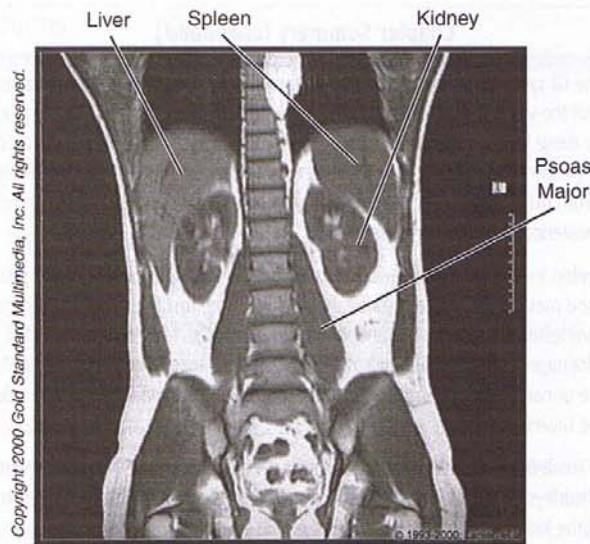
Abdomen: MRI, Coronal
